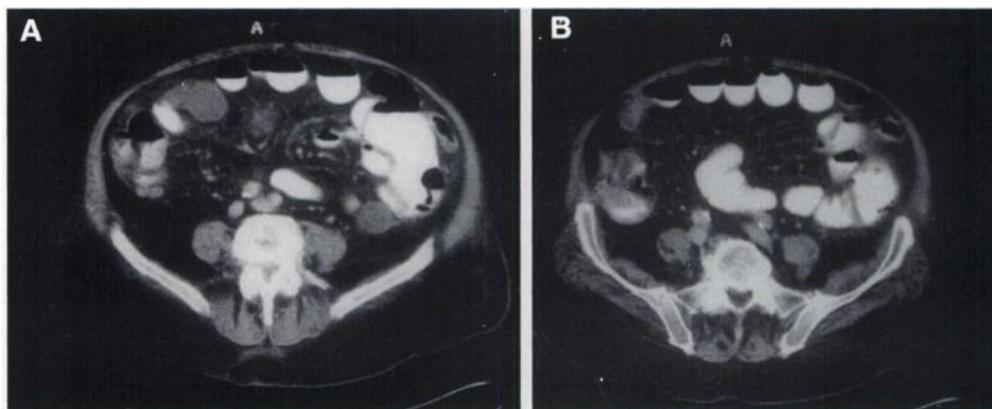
Two CT images at different levels of the pelvis demonstrate LLQ fluid collection/abscess (A) and absence of small intestine wall thickening (B).
